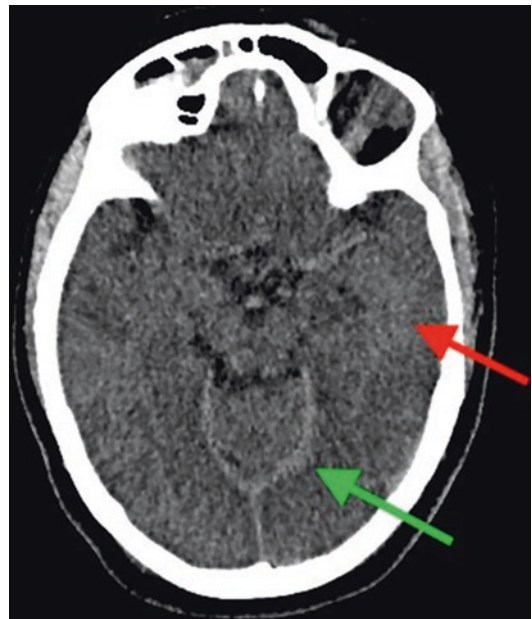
Axial CT image demonstrating global hypoxic injury with a reversal of gray-white matter density (red arrow). As a result the posterior falx cerebri and tentorium cerebelli are relatively dense, creating the 'pseudosubarachnoid' sign (green arrow)
